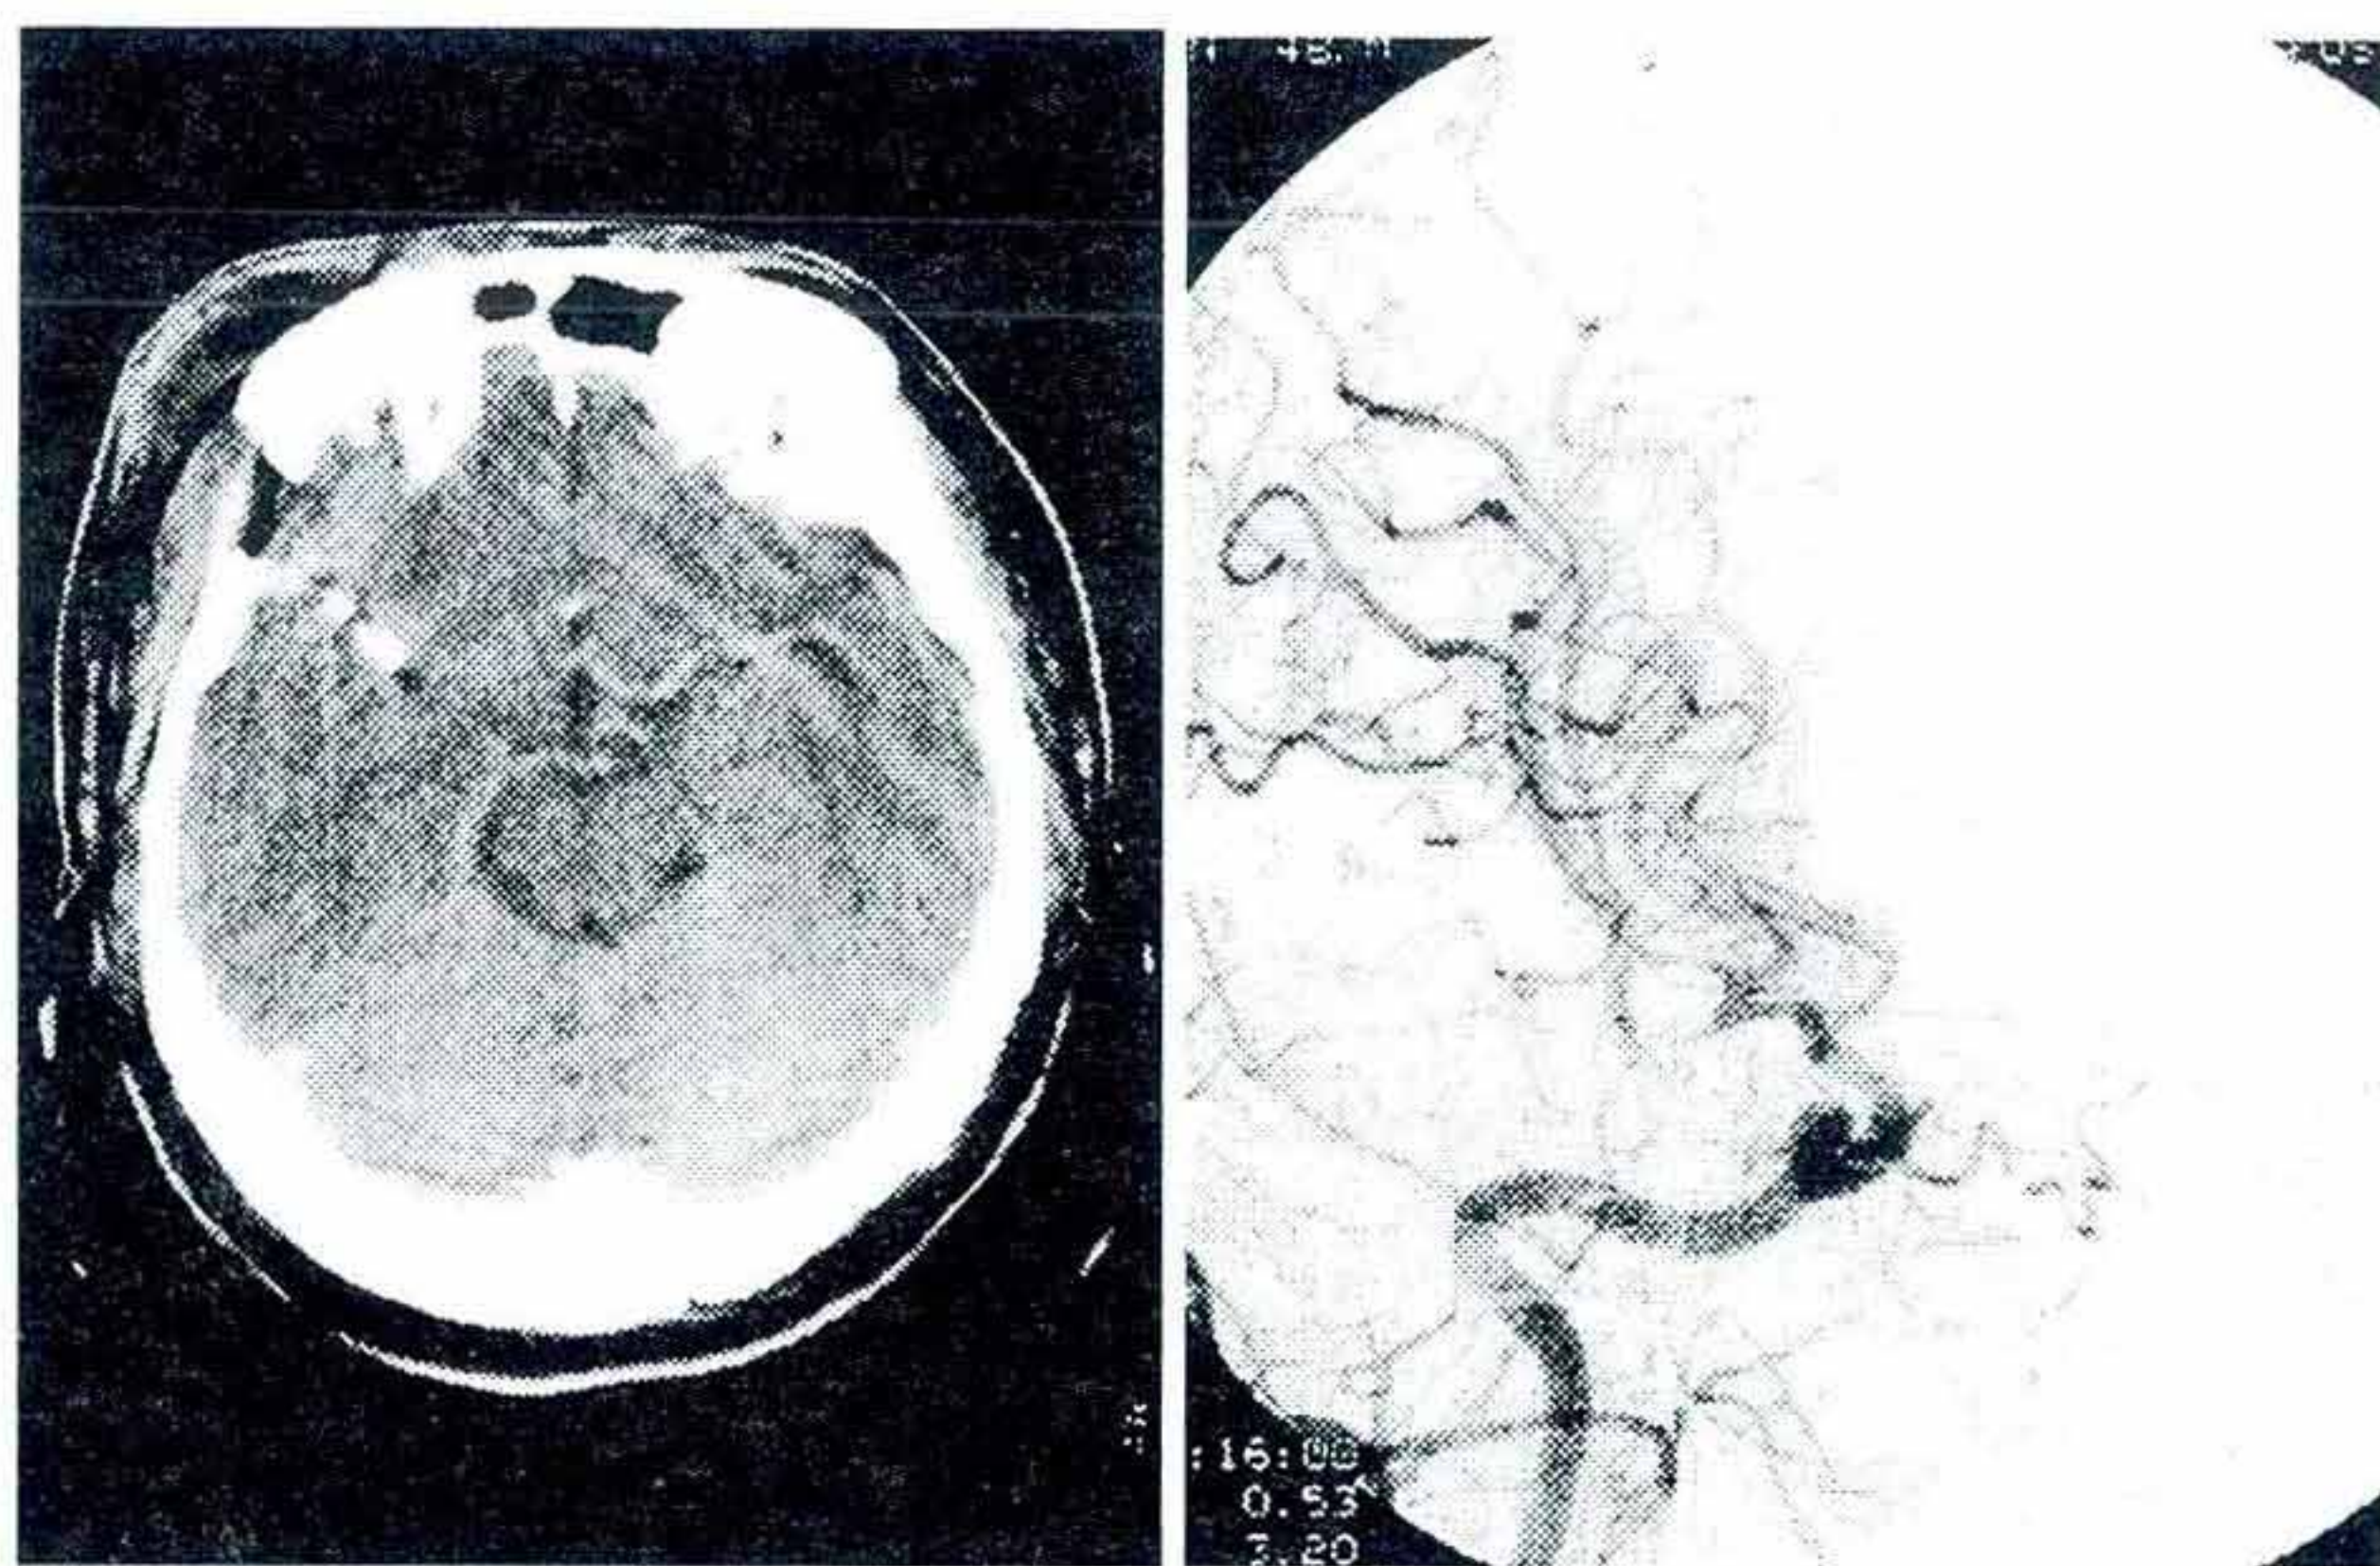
The postoperative results of this patient. CT scan showed the clip was put in the right place and the bone flap was suitable (A). DSA showed no aneurysm sac was remained. The MCA bifurcation aneurysm was completely clipped (B).
